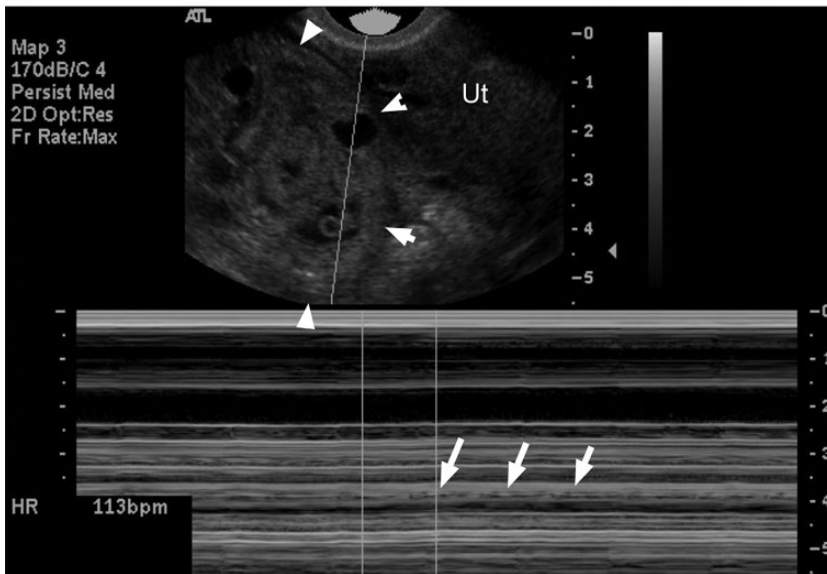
(a) Transvaginal ultrasound image demonstrating an extra-uterine yolk sac within a mass adjacent to the empty uterus (UT) in the right adnexa (RT ADN). (b) TVU of the same case showing greater detail of the empty uterus (Ut) with a large complex adnexal mass (arrowheads) containing a yolk sac and foetal pole. M-mode reveals cardiac activity (arrows).
